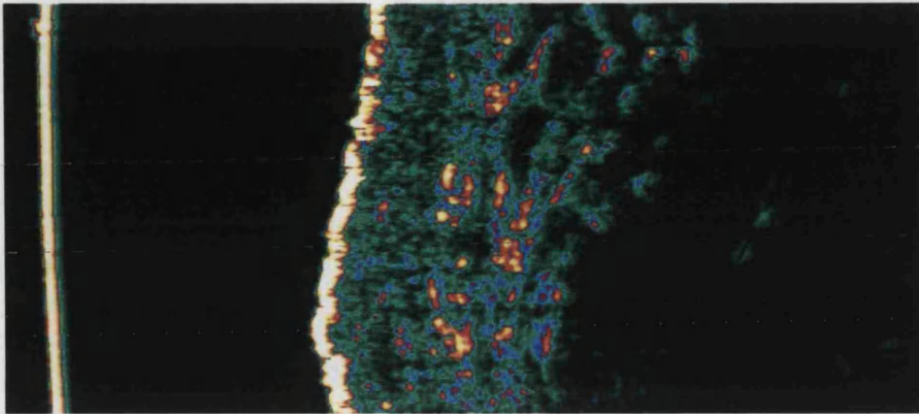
A typical ultrasound image of skin taken from the dorsum of the foot.
